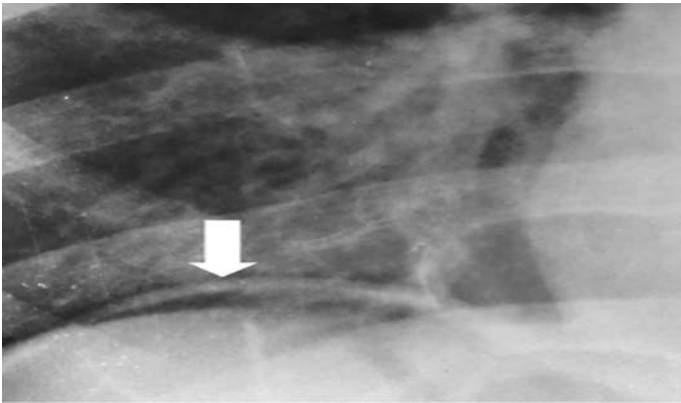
Enlarged part of the chest radiograph with white block arrow pointing to the pneumoperitoneum (Magnification 4X).
